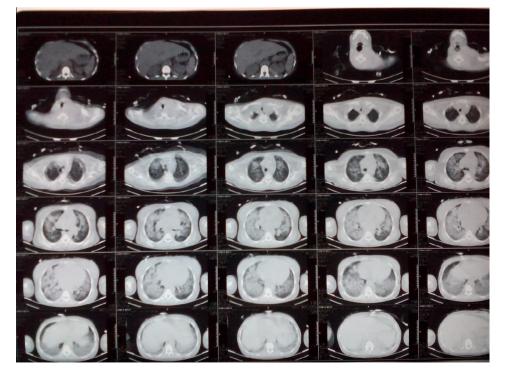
CT scan showing diffuse bilateral lung infiltrates.
